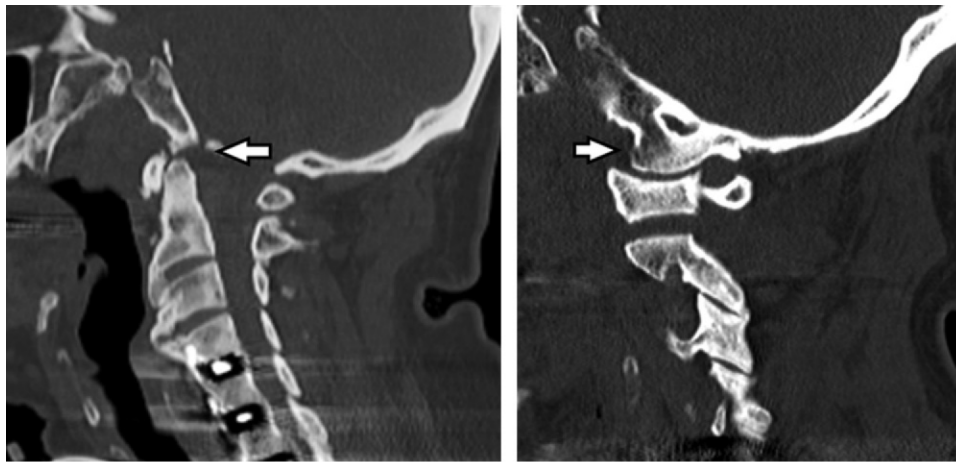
Type III AOD. (a) Sagittal CT image shows posterior displacement of the head with respect to the cervical spine. A fragment of the occipital bone is seen near the basion (arrow). (b) Left parasagittal reformatted CT image shows posterior displacement of the occipital condyle (arrow) with respect to the lateral mass of C1.
